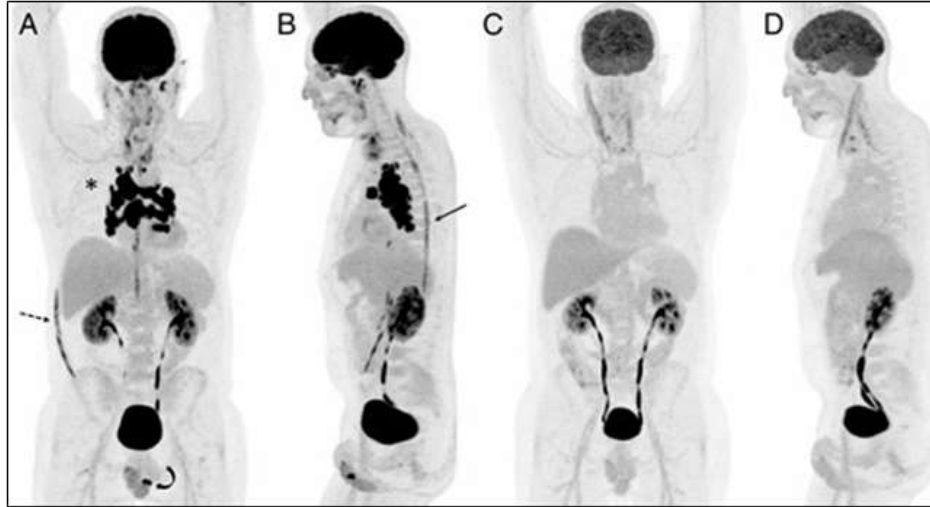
¹⁸F-FDG PET/MRI for Diagnosis and Treatment Efficacy Evaluation of Spinal Sarcoidosis [8].
